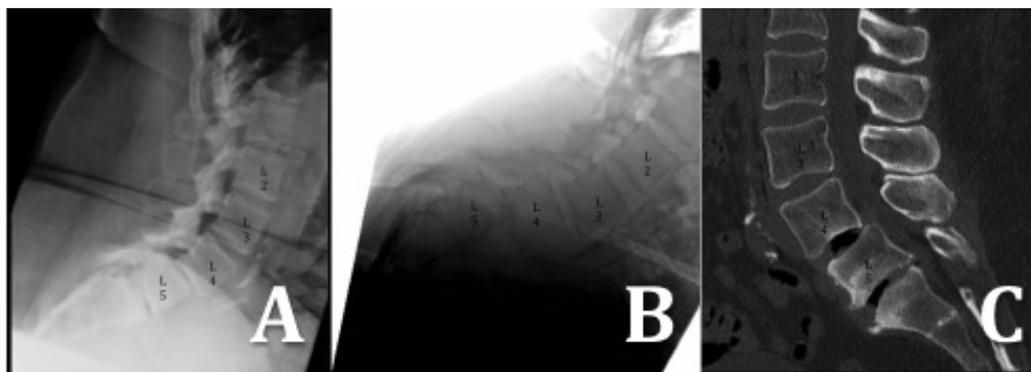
A) Standing x-ray of the lumbar spine demonstrates grade 1 anterolisthesis of L4 on L5 in 2005. B) In 2013, spondylolisthesis progressed to grade 3 anterolisthesis L4 on L5 and grade 2 anterolisthesis of L3 on L4. C) CT in 2013 demonstrates a near complete reduction of her olisthesis at L3/4 and L4/5 when the patient is lying supine.
